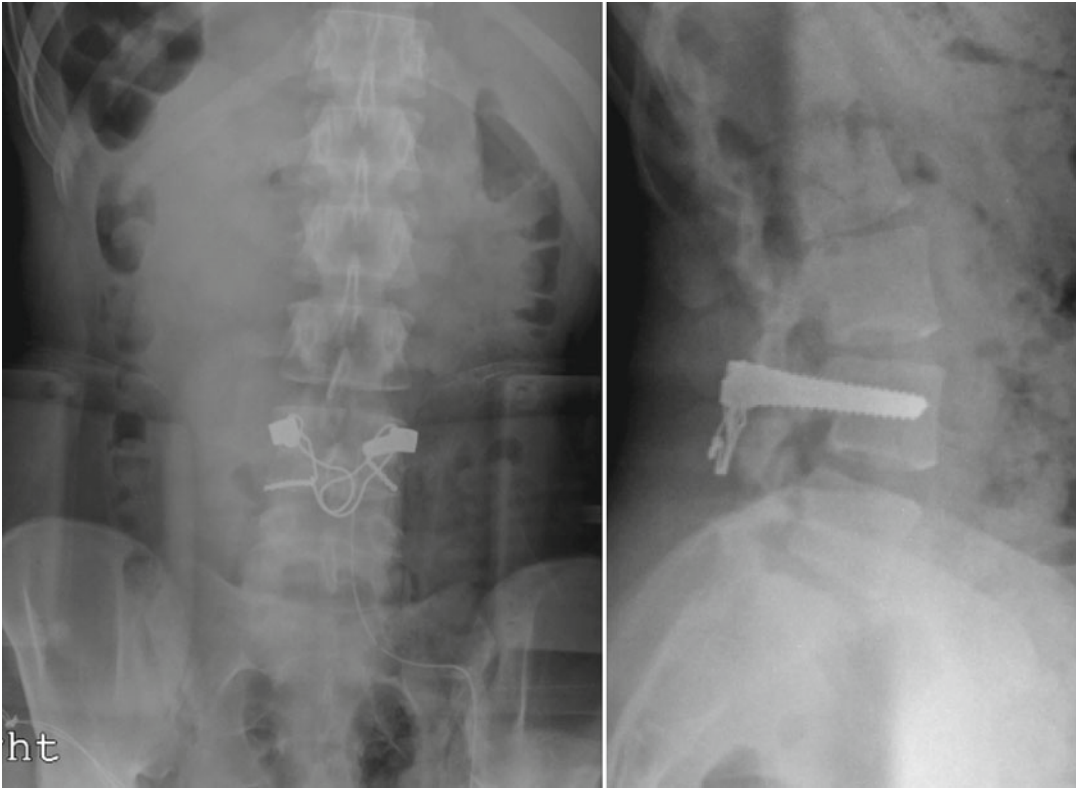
AP and lateral radiographs demonstrating postoperative changes after surgical pars repair at L4. A bilateral pedicle screw/compression wiring technique was utilized to create stability and compression across the pars defect
